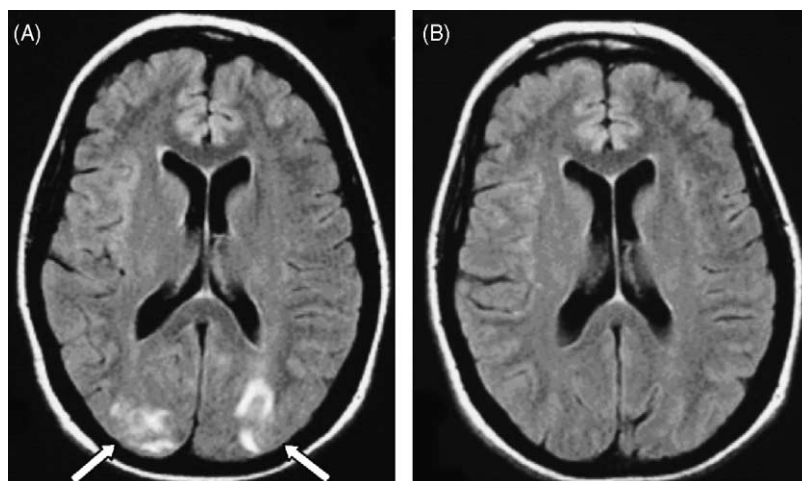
Initial MRI study in a patient with severe hypertension, headache, confusion and visual disturbances reveals typical subcortical edema in the occipital regions with only minimal cortical involvement (arrows) on axial FLAIR sequence (A). One week later, after antihypertensive treatment and clinical improvement, follow-up MRI study reveals complete resolution of the lesions on FLAIR images (B).
